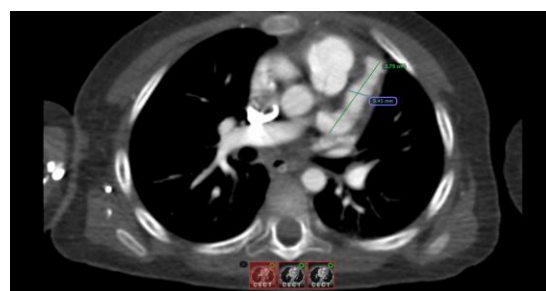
Cardiac CT showing a left anterior descending aneurysm.
